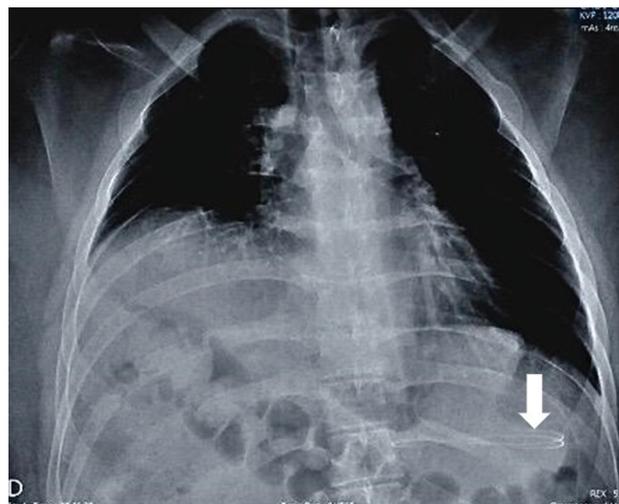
Chest X-ray showing a ventriculoperitoneal (VP) shunt catheter in the gastric region
